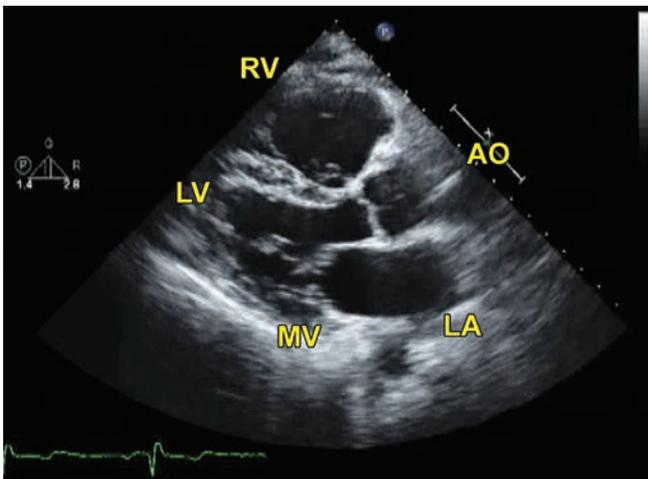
Parasternal long axis view. Unremarkable except mild thickening and prolapse of AV.
